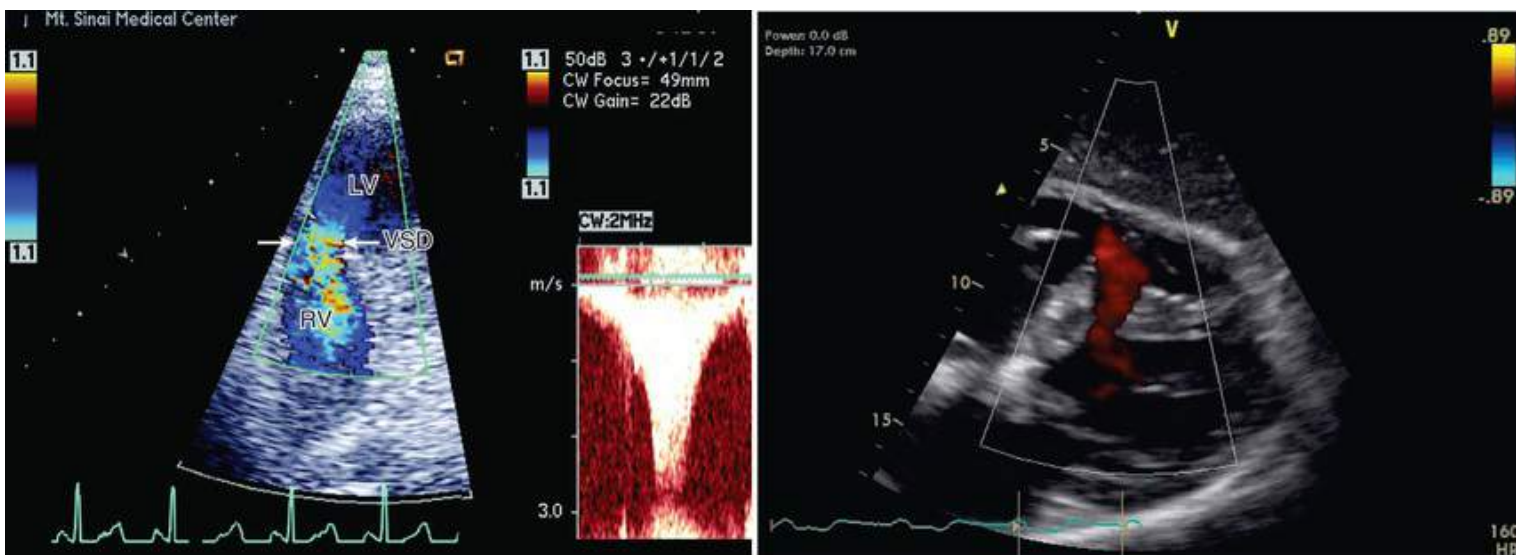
Echocardiography of two ventricular septal defects (VSDs) that developed after STEMI. A close-up of the ventricular septum demonstrates turbulent systolic color flow Doppler across a VSD (*white arrows*), and continuous-wave Doppler demonstrates systolic flow across a VSD (left). A subcostal view demonstrates color flow Doppler across a VSD (right). LV, Left ventricle; RV, right ventricle. (Left, From Kamran M, Attari M, Webber G. Images in cardiovascular medicine. Ventricular septal defect complicating an acute myocardial infarction. *Circulation* 2005;112:e337; Right, from Brigham and Women's Hospital, 2013.)
